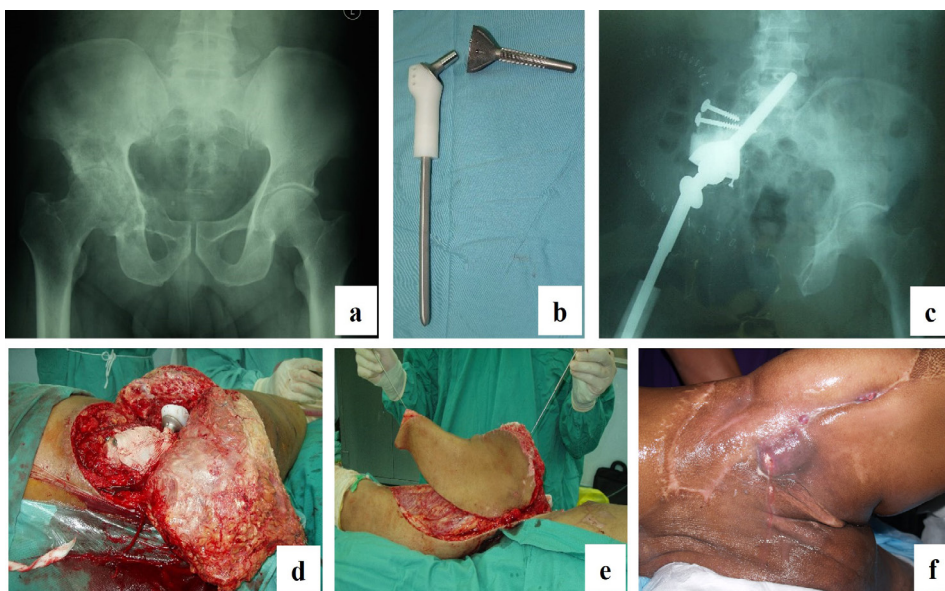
The patient in Case #3 was surgically treated for right periacetabular chondrosarcoma. Plain radiograph showed involvement of the right ilium, ischiopubic, and proximal femur (a). Following surgical resection, the bony defect was reconstructed with an endoprosthesis (b and c), while a free myocutaneous flap was used to cover the large soft tissue defect (d and e). Unfortunately, the patient experienced persistent polymicrobial chronic infection (f), which was subsequently resolved after an external hemipelvectomy
